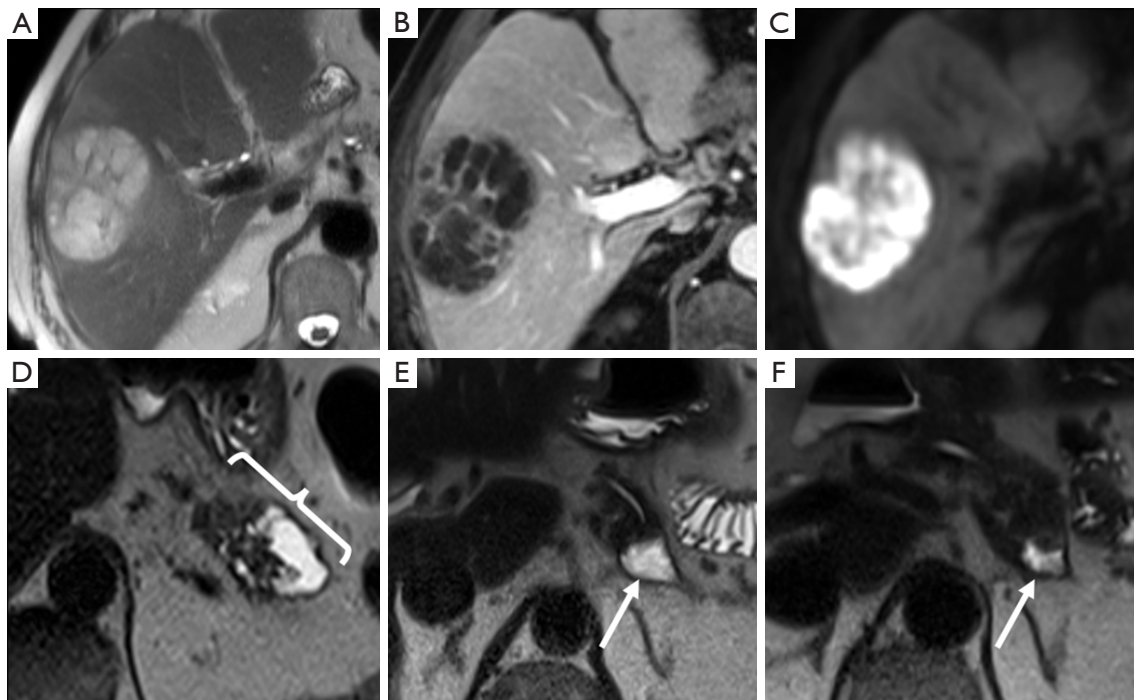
Unexpected and expected postoperative findings. Axial (A) T2, (B) venous, and (C) DWI MR images demonstrate a multiloculated hepatic abscess with rim and septal enhancement and diffusion restriction. In a different patient, axial T2 images (D) preoperatively demonstrates an invasive PDAC arising in IPMN (bracket), with an expected small, simple appearing, and diminishing fluid collection (arrow) at the surgical margin at (E) 3 months and (F) 12 months postoperation. DWI, diffusion-weighted imaging; MR, magnetic resonance; PDAC, pancreas ductal adenocarcinoma; IPMN, intraductal papillary mucinous neoplasm.
